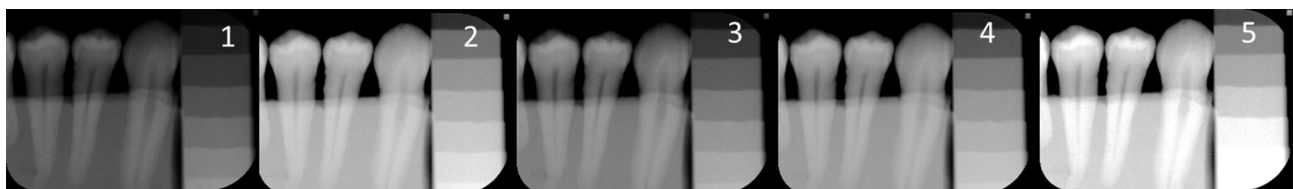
Radiographic images randomly displayed in a slide for subjective image quality evaluation.
